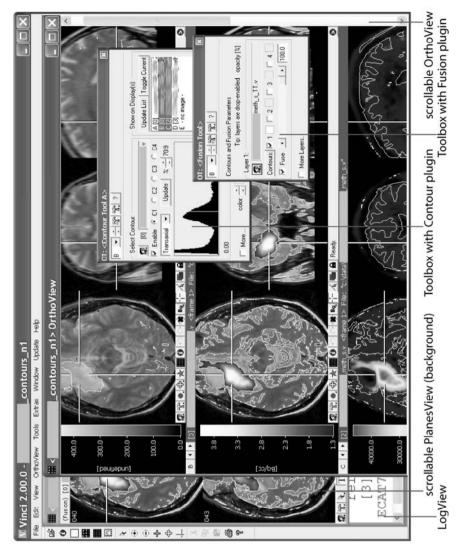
Screenshot of VINCI presenting data for surgery planning. Here: full screen in projector resolution (1024×768 pixels). Observe that all major widgets are scrollable and that toolboxes can be positioned at arbitrary positions (or closed). VINCI projects can also be defined on much larger screens, e.g. in multi-display settings: if restored when running a different resolution (e.g. for projector presentation) widgets are resized and respositioned automatically. OrthoView top row: T2-MRI with contrast agent, bottom row: full range Methionine-PET (iso-contours defined on the MRI to validate registration accuracy), middle row: "tumor-normalized" (s.b.) Meth-PET fused with MRI.
